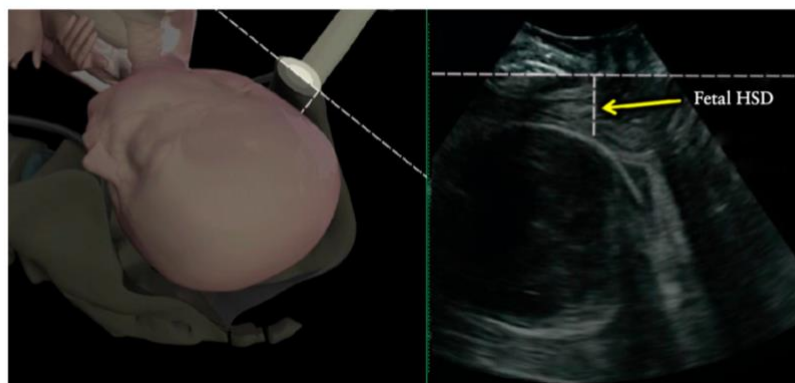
Measurement of head-symphysis distance (Adapted from ISUOG Practice Guidelines: intrapartum ultrasound)³
